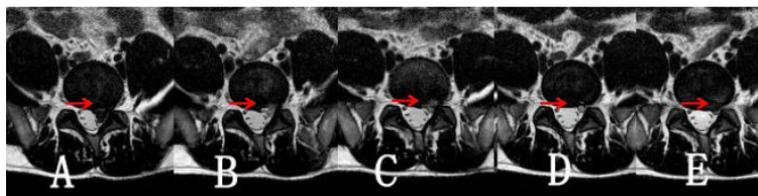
MRI cross section (red arrow indicates the operative area)
